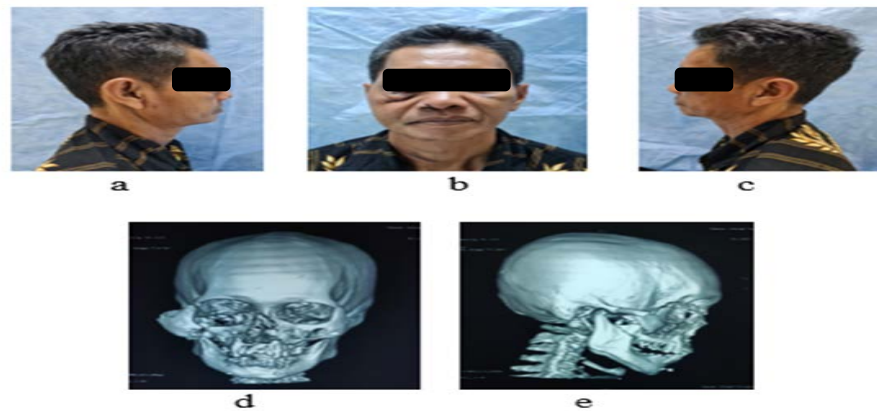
Clinical examination on images (a), (b), (c) and CT scan of the head with 3-D reconstruction in figure (d), (e)
